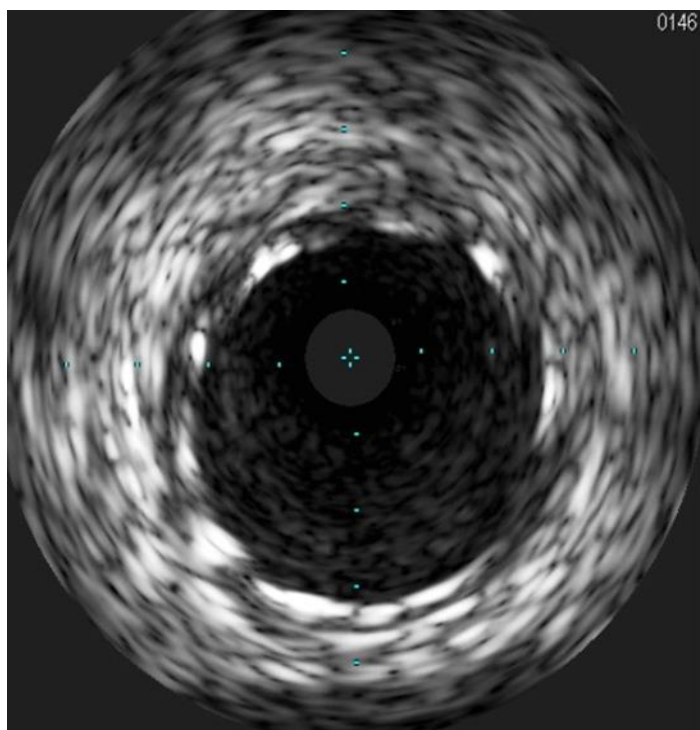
Post stenting intravascular ultrasound showing a well expanded and well apposed stent.
